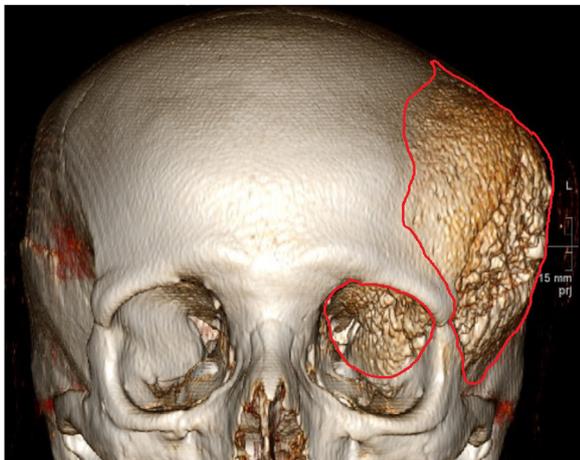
Three-dimensional computed tomographic image of lesion (outlined in red) involving the left lateral orbital wall. This was subsequently mirrored to create a normal left orbit.
